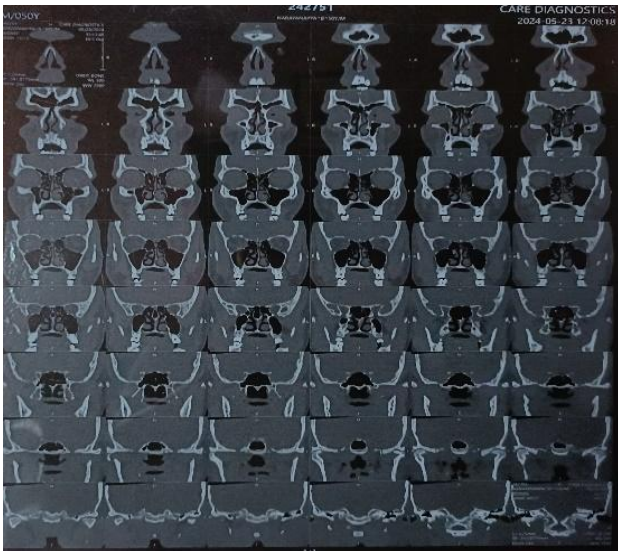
Results of x-ray.
